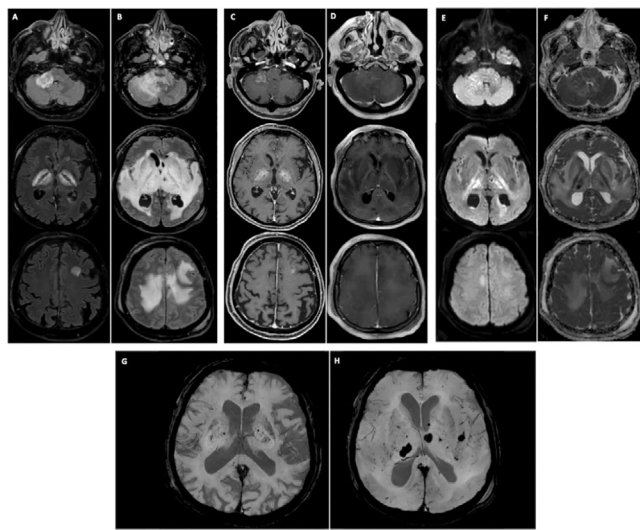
Brain MRI of the patients at ER arrival and at follow-up five days later.
